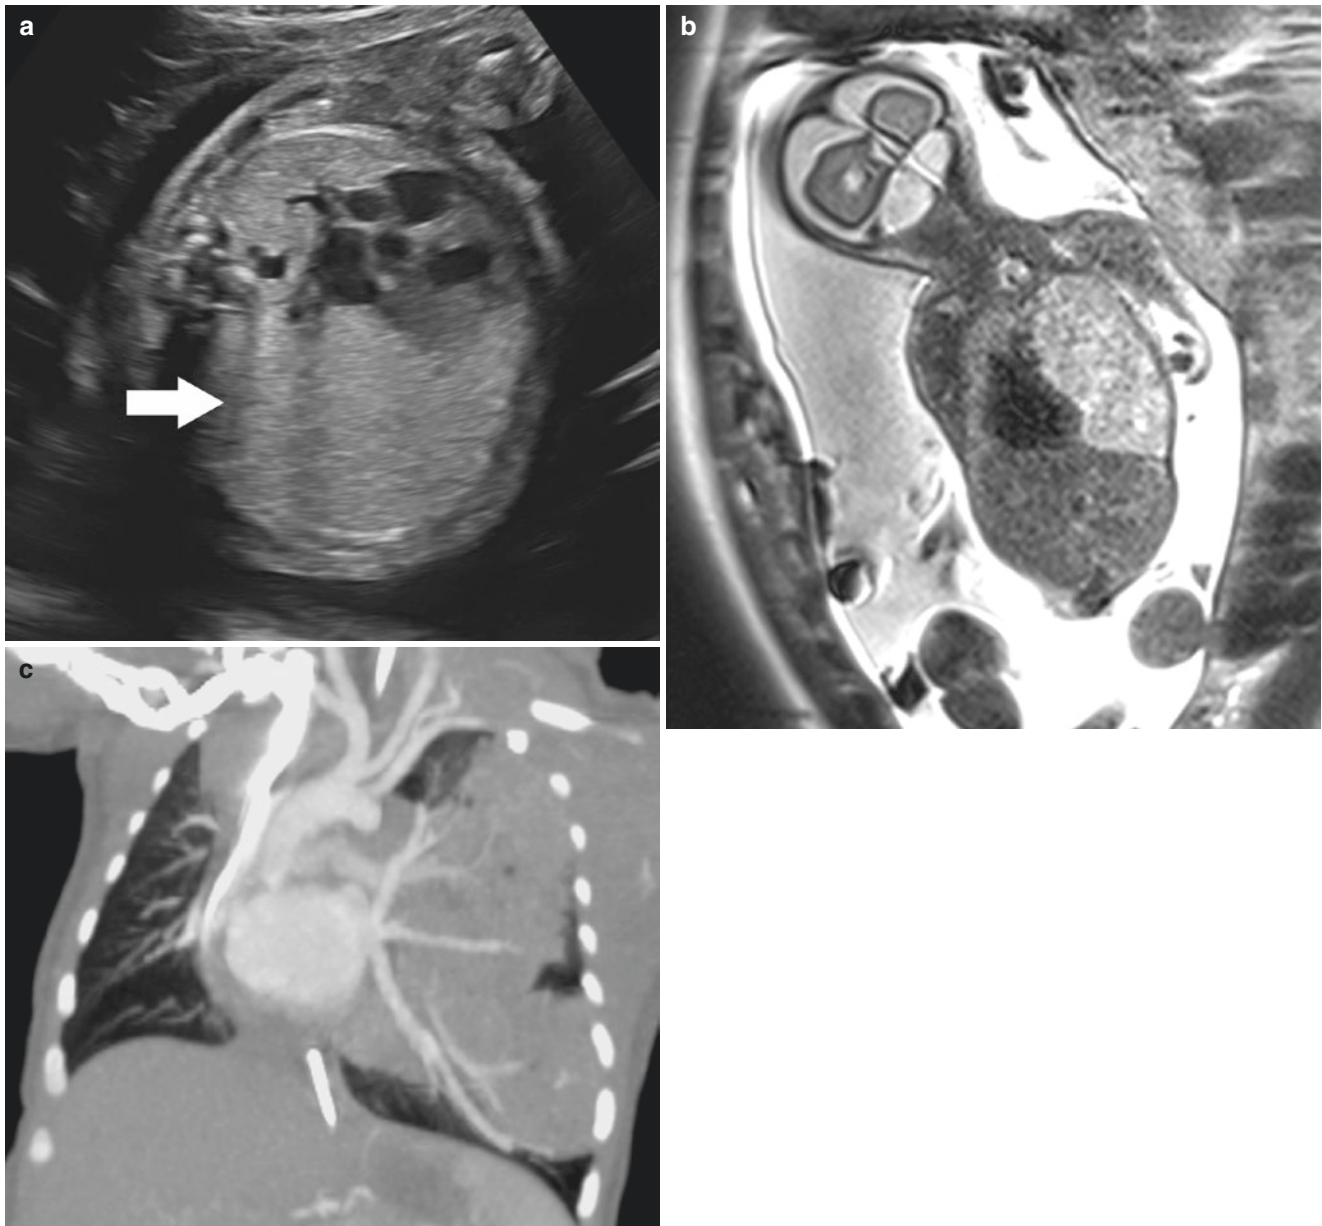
Fetal lung interstitial tumor (FLIT). (a) Axial US image at 27 weeks gestation demonstrates an echogenic mass (arrow) deviated the heart to the right. (b) Coronal T2w MR image on the same date confirms the presence of a heterogeneous mass compressing the diaphragm inferiorly and shifting the mediastinum to the right. This was
